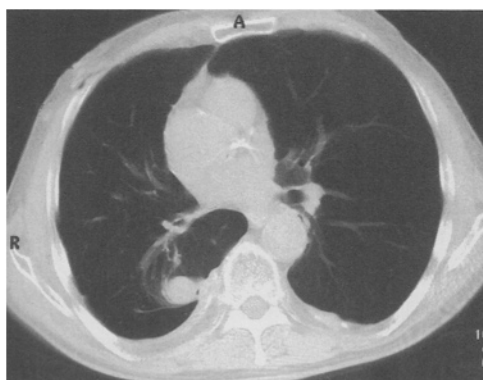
CT scan : right rounded atelectasis
